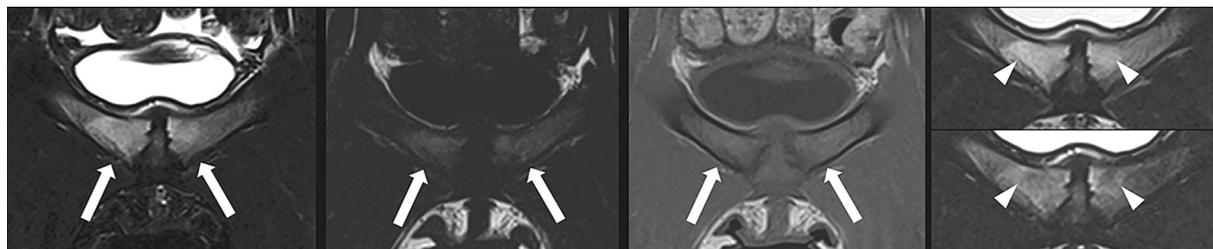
Whole-body MRI in a 17-year-old adolescent. Details from the pubic bones, showing a) symmetrical high signal on T2 Dixon water-only images (arrows). b) On the T2 Dixon fat-only image the signal is difficult to evaluate and appears as not reduced (arrows). c) The pubic bones have homogeneous, not decreased signal on the T1 weighted image (arrows). d) On the in-phase (upper image) there is increased signal in the pubic bones (arrowheads), on the out-of-phase (lower image) there is patchy reduced signal in the same areas confirming the mixed water and fat content.
